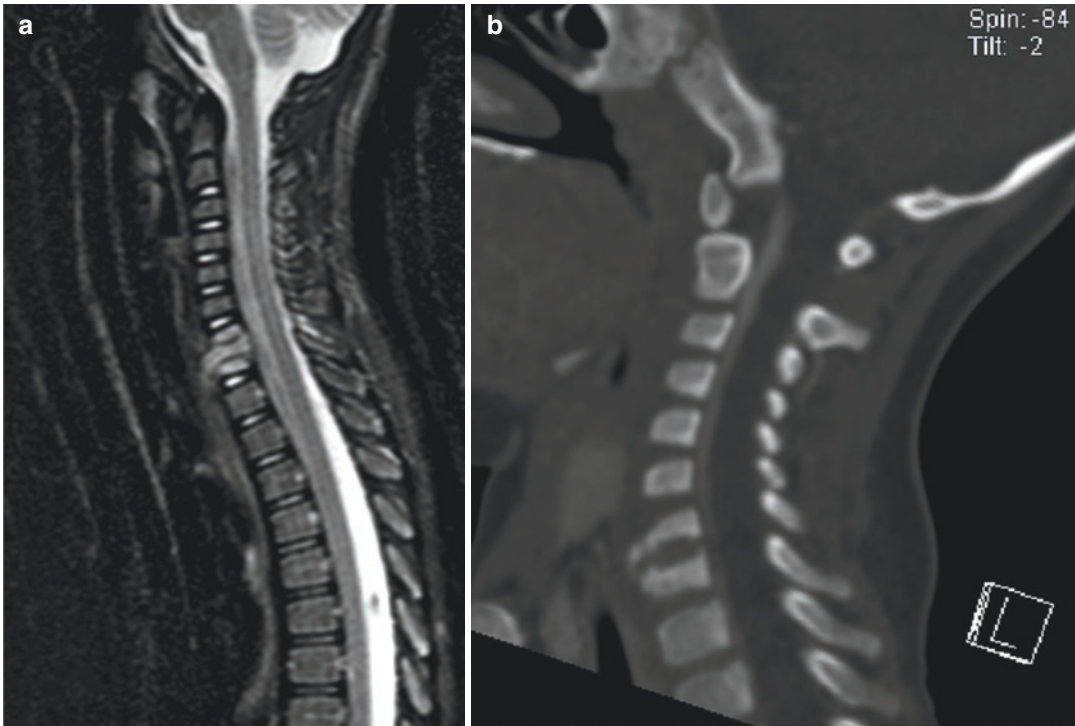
Late complication of ingested FB—Same patient as in Fig. 26.3. Two months later the patient presented with unexplained neck stiffness. (a) MR imaging
